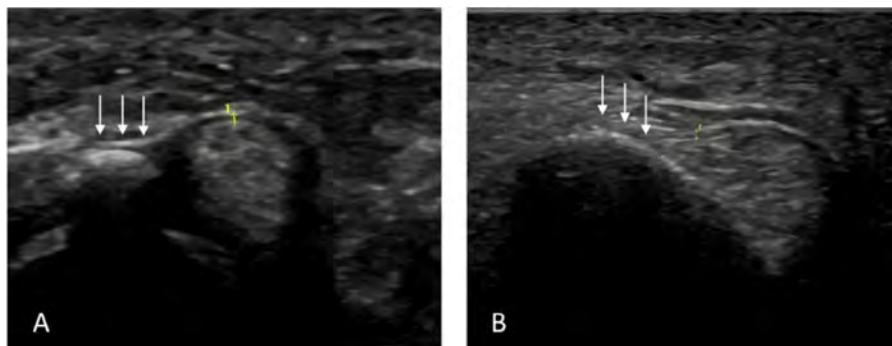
Ultrasound longitudinal scans of the annular pulleys entheses. A) A1 enthesis at the sesamoid bone. B) A2 enthesis in the proximal phalanx. White arrows: Annular pulley entheses. Yellow stars: Dorsal and volar limits of the pulley.
